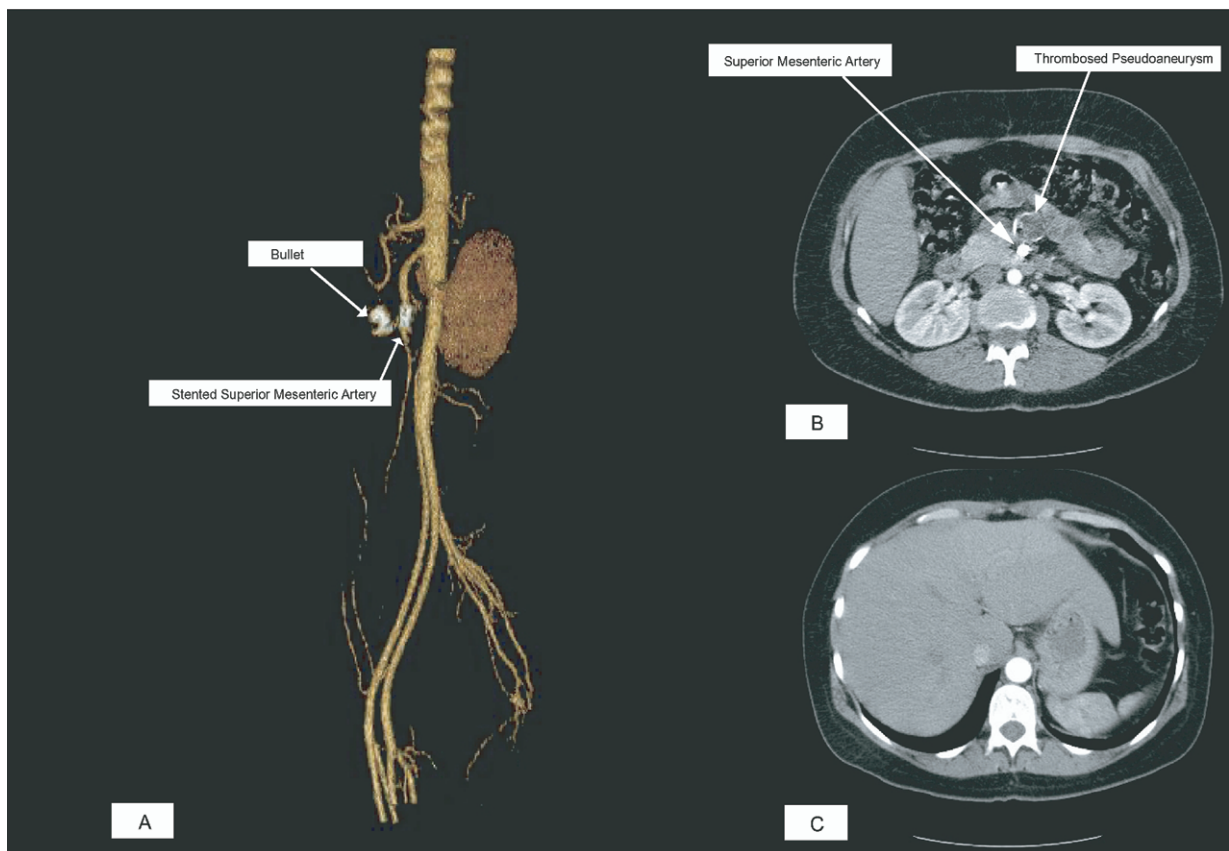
Posttreatment computed tomography scan of abdomen. A, Three-dimensional reconstruction of the aorta and superior mesenteric artery (SMA). B, Shows the SMA, thrombosed pseudoaneurysm, and absence of early contrast in the superior mesenteric vein.
